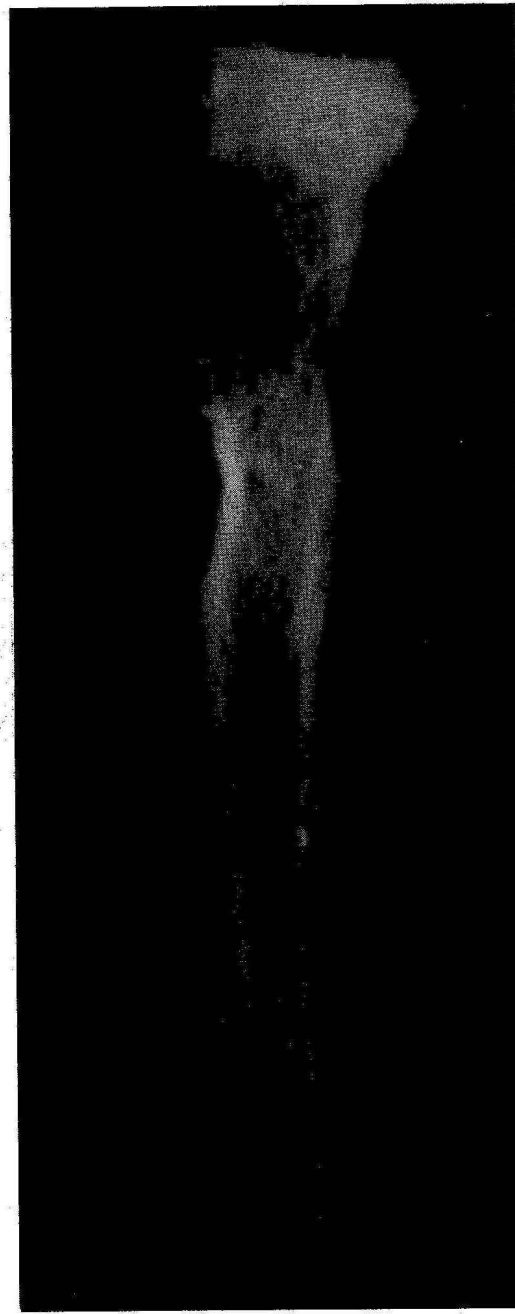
X-ray of lateral view of the proximal diaphysis of the tibia, showing chronic inflammatory changes (X-ray picture: S. Strnad).
